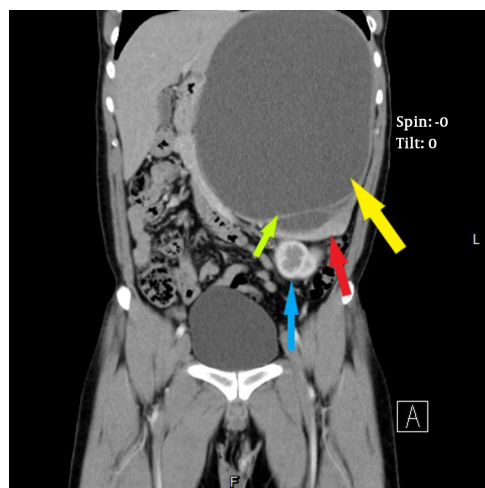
Coronal view of contrast-enhanced CT of the abdomen; red arrow: the spleen; yellow arrow: the cyst; green arrow: the septum; blue arrow: the kidney
